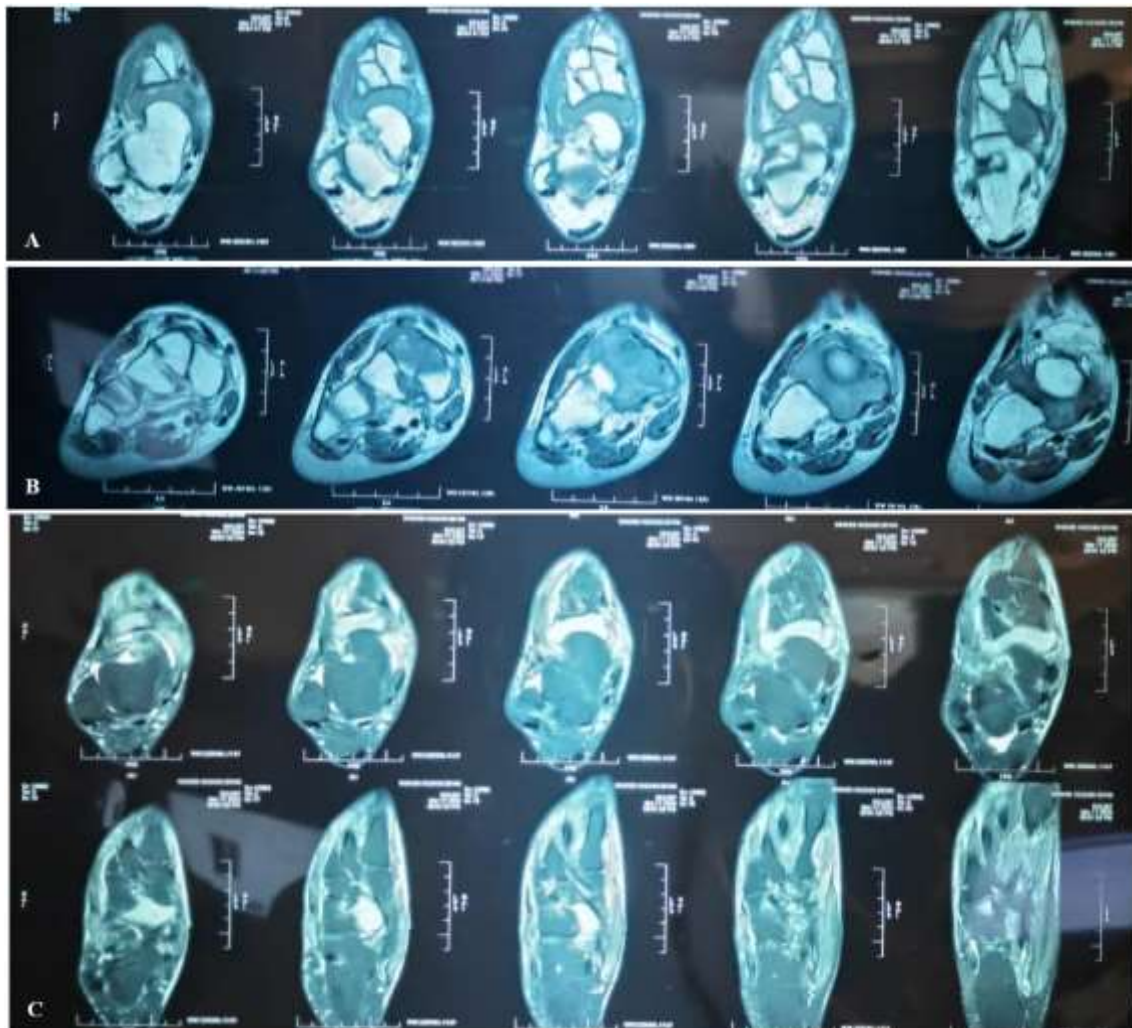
(A-C): MRI of right foot (T1WI and T2WI) showing a well defined expansile lytic lesion in the navicular bone which appears hypointense on T1 weighted images and heterogeneously hyperintense on T2 weighted images. No evidence of matrix mineralization or periosteal reaction.
